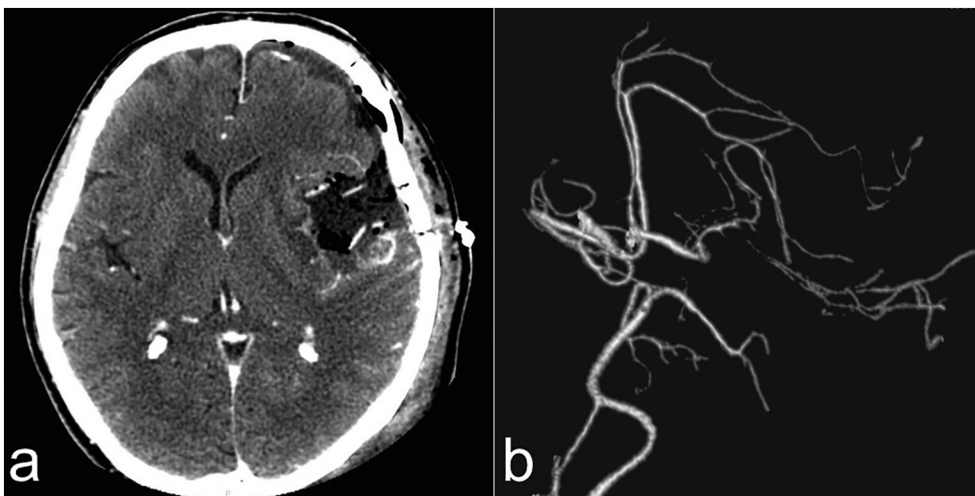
Postoperative CT. a) Contrast-enhanced image showing normal postoperative findings, with carmustine wafers lying on the wall of surgical cavity, and small enhancing remains in the posterior lateral border; b) CT-angiography revealed vasospasm of the left middle cerebral artery (M2-M3 branches).
